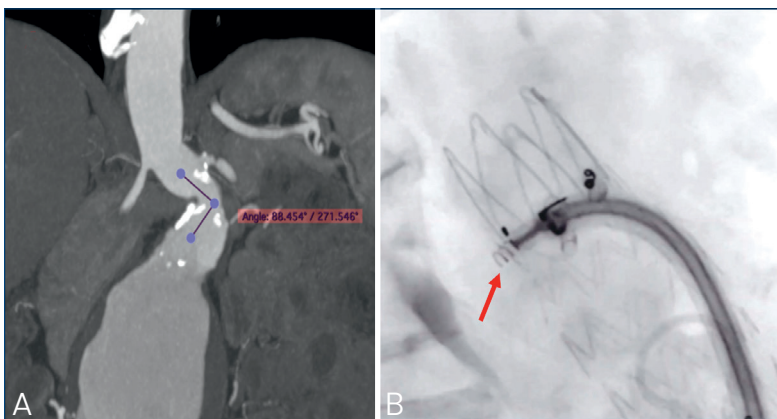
● A) CT scan of a AAA with angulated neck; B) positioning of an EndoAnchor (indicated by the arrow).
